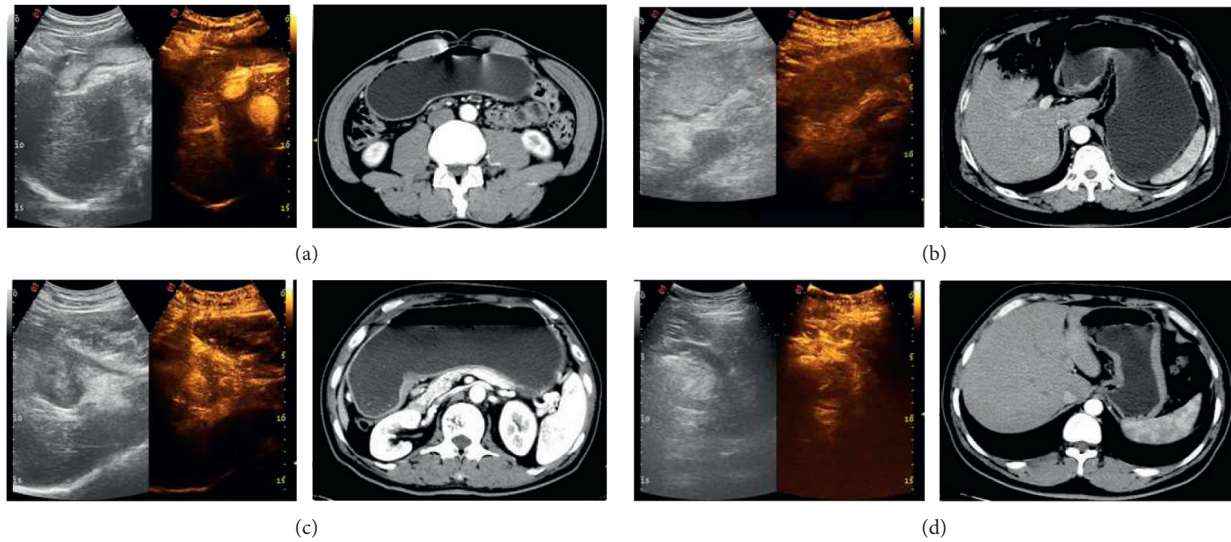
DCEUS image of typical cases. Note: in (a), (b), (c), and (d), the left images were oral gastrointestinal contrast agent ultrasound images, the middle images were double-contrast ultrasound images, and the right images were enhanced MSCT images. (a) An ultrasound image of a 59-year-old male patient; he was finally diagnosed as a moderately differentiated adenocarcinoma of the antrum (pT1 staging). DCEUS showed focal thickening of the gastric wall, with focal positive development of the middle layer in the inner layer of the gastric wall and clear boundary with the outer layer, and it was judged that the tumor infiltrated into the muscularis mucosa. MSCT showed focal gastric wall thickening, and the lesion did not exceed the low-density zone of submucosa (preoperative diagnosis cT1 staging). (b) An ultrasound image of a 60-year-old female patient. She was finally diagnosed as poorly differentiated adenocarcinoma with ulcerative gastric antrum (pT2 staging). DCEUS showed that the whole gastric wall of the lesion was thickened and positively developed, and the outer edge of the lesion was intact and smooth, and it was judged that the tumor infiltrated into the muscle layer; MSCT showed that the gastric wall was thickened, the lesion broke through the slightly strengthened muscle layer of the submucosa, the outer surface of the stomach around the lesion was clear and smooth, and the fat surface around the stomach was clear (preoperative diagnosis of cT2 staging). (c) An ultrasound image of a 64-year-old female patient. She was finally diagnosed as a poorly differentiated adenocarcinoma with an ulcerative type of lesser curvature of stomach (pT3 staging). DCEUS showed that the whole gastric wall of the lesion was obviously thickened and showed positive development, and the outer layer of the tumor was vague and serrated, breaking through the adventitia, but not invading the adjacent structures, and it was judged that the tumor infiltrated into the subserosal layer; MSCT showed gastric wall thickening, irregular fat infiltration around the stomach, and uneven serosal surface (preoperative diagnosis of cT3 staging). (d) An ultrasound image of a 58-year-old male patient. He was finally diagnosed as poorly differentiated adenocarcinoma of the lesser curvature ulcerative type (pT4 staging). DCEUS showed that the whole layer of gastric wall of the lesion was thickened and showed positive development, the tumor invaded the outer serous, and the tumor broke through serosa; MSCT showed that the tumor broke through the perigastric adipose tissue and serosa, accompanied by the expansion and invasion of adjacent organs or structures (preoperative diagnosis of cT4 staging).
